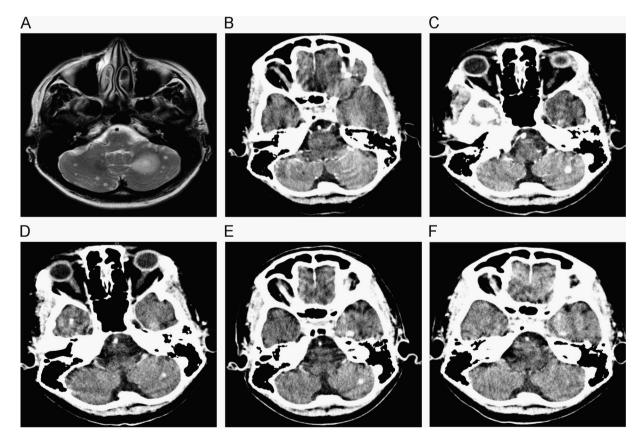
Magnetic resonance imaging (MRI) and computed tomography (CT) scans showing the process of brain metastases: at initial diagnosis (A), after first line therapy with whole brain radiation therapy (WBRT) and erlotinib (B), at first relapse (C), after repeated WBRT and continued erlotinib (D), at second relapse (E), after therapy with gefitinib (F).
